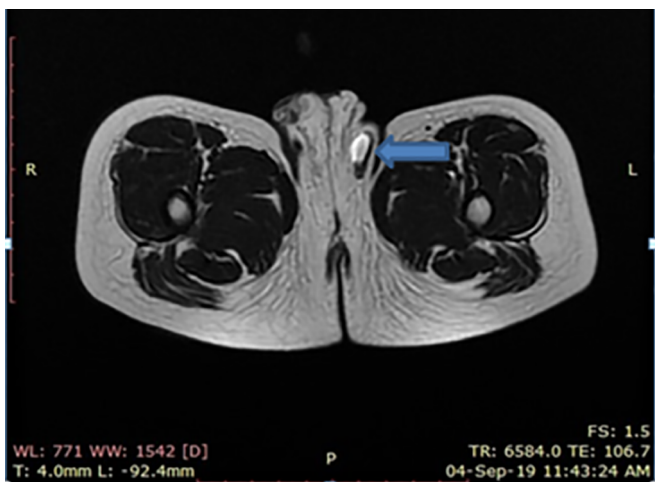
MRI demonstrates torsion of the left testis with perineal dystopia.
